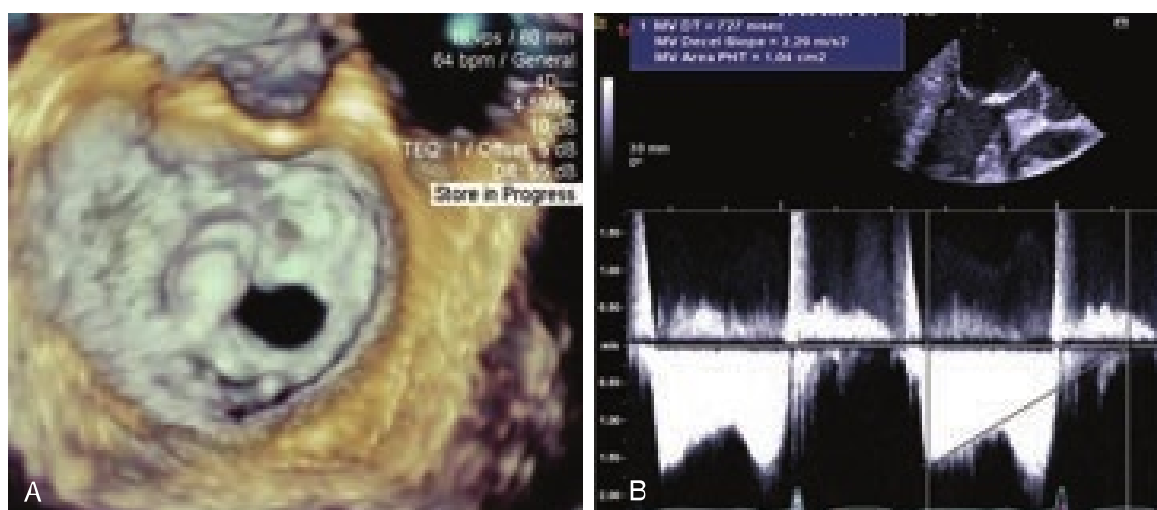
Transesophageal echocardiography images of a patient with severe rheumatic heart disease of the mitral valve showing (A) three-dimensional image displaying heavily calcified leaflets with mitral annular calcification and the classic fish-mouth view, and (B) transmitral flow and calculation of the pressure half-time to estimate mitral valve area.
